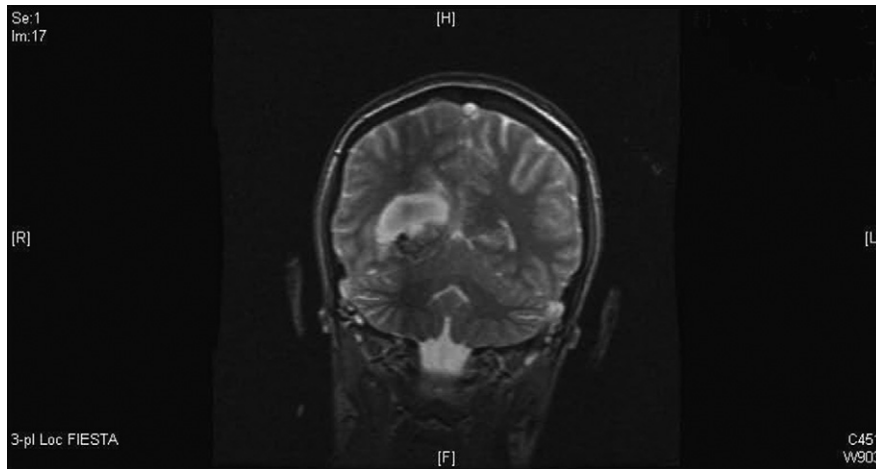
MRI shows intraventricular and subarachnoid hemorrhage affecting the right occipital-temporal lobes, patient 2.
